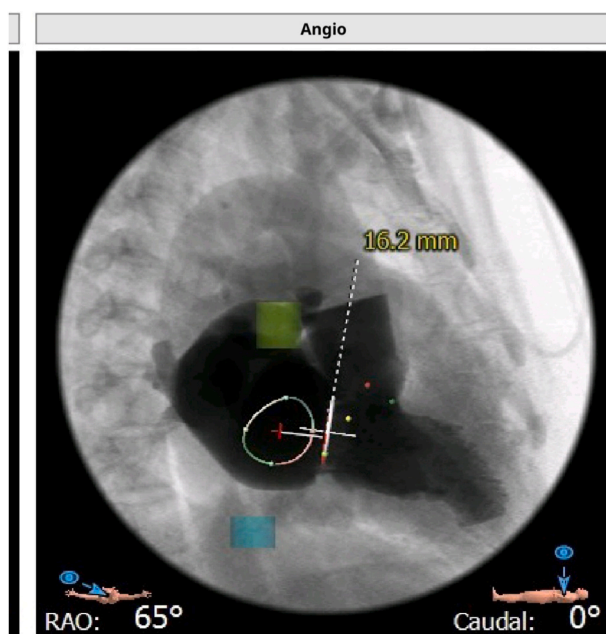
CT Pre procedural mitral and aortic annular distance.
